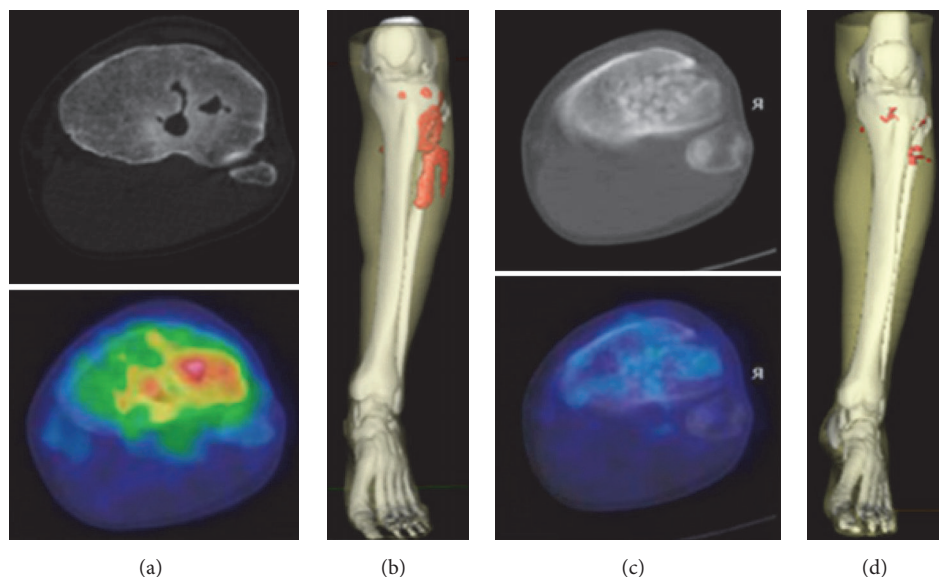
[^{68}Ga]Ga-citrate PET/CT examination of a patient affected by acute osteomyelitis before (left panel) and after (right panel) surgical curettage showing uptake in the transaxial (a, c) and 3D reconstruction images (b, d; red area). Absence of the uptake after the therapy confirms complete response to the treatment. Adapted from [19].
